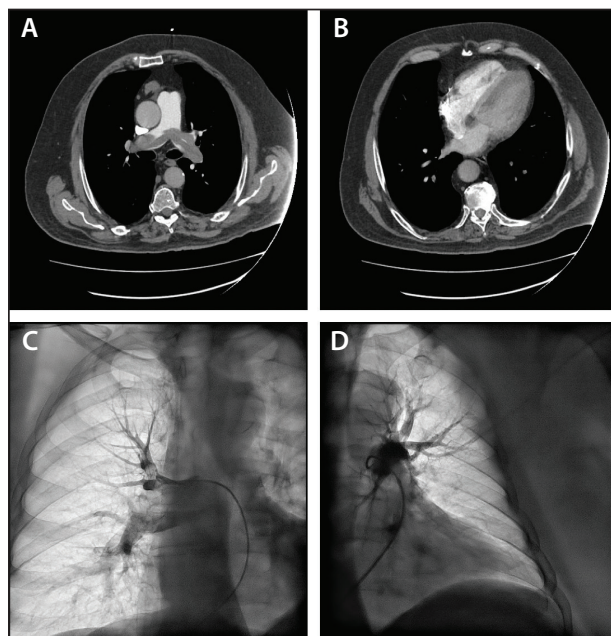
Diagnostic imaging. CTA demonstrating an extensive saddle PE (A) and a modestly enlarged right ventricle (B). Pulmonary angiogram confirming large clot burden in both the right (C) and left (D) PAs.
